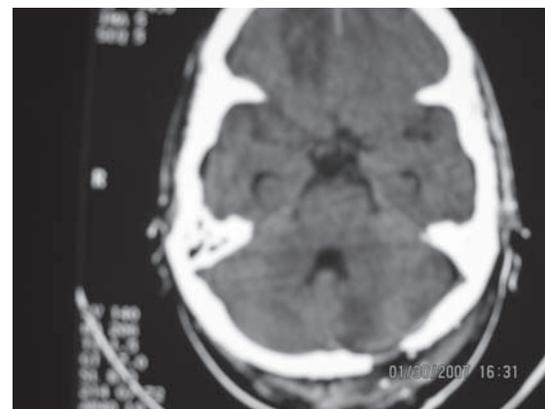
Post operative CT showing EDH evacuation
